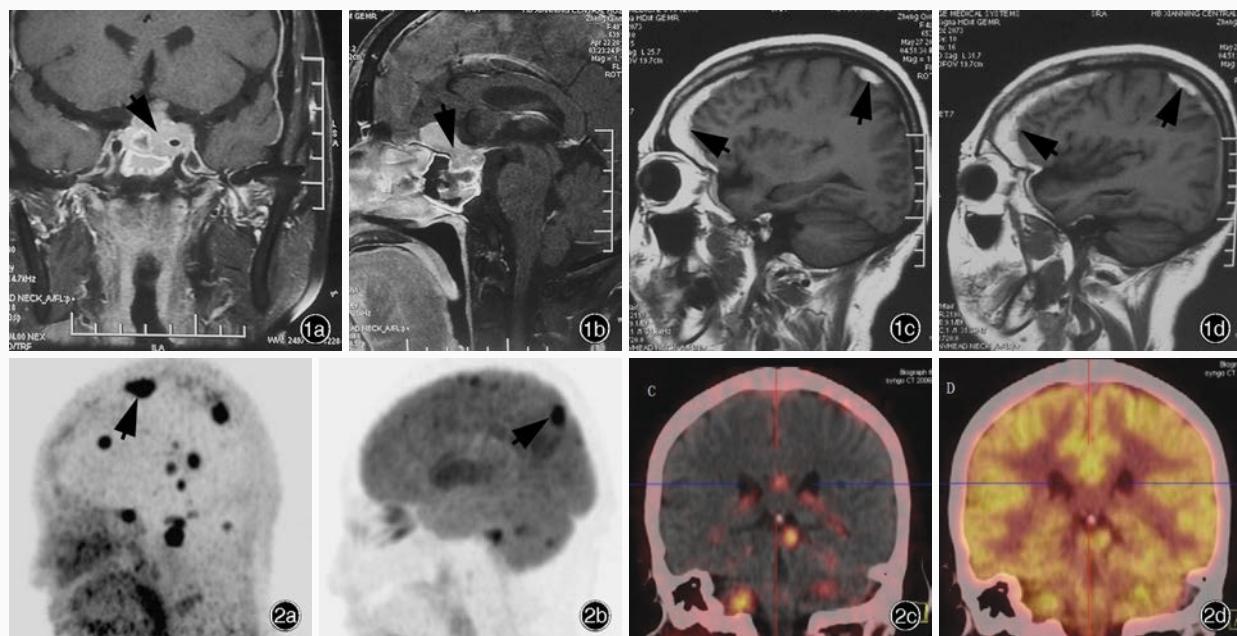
首次手术前后头部MRI检查所见 1a 首次手术前冠状位增强T₁WI显示,蝶鞍扩大、鞍底下陷,病灶明显强化,呈高信号(箭头所示) 1b 首次手术后矢状位增强T₁WI显示,蝶鞍扩大、鞍底下陷,病灶明显强化,呈高信号(箭头所示) 1c,1d 首次手术后矢状位T₁WI显示,左侧额顶颞叶、右侧额叶慢性硬膜下血肿形成(箭头所示) 图2 第2次手术后PET-CT扫描所见 2a ⁶⁸Ga-TATE-PET CT最大密度投影图显示病灶数目明显多于MRI所示(箭头所示) 2b ¹⁸F-FDG-PET CT最大密度投影图显示病灶数目明显多于MRI所示(箭头所示) 2c ⁶⁸Ga-TATE-PET CT显示颅内多发高摄取信号(红黄色区域所示) 2d ¹⁸F-FDG-PET CT显示颅内多发高摄取信号(红色区域所示)
